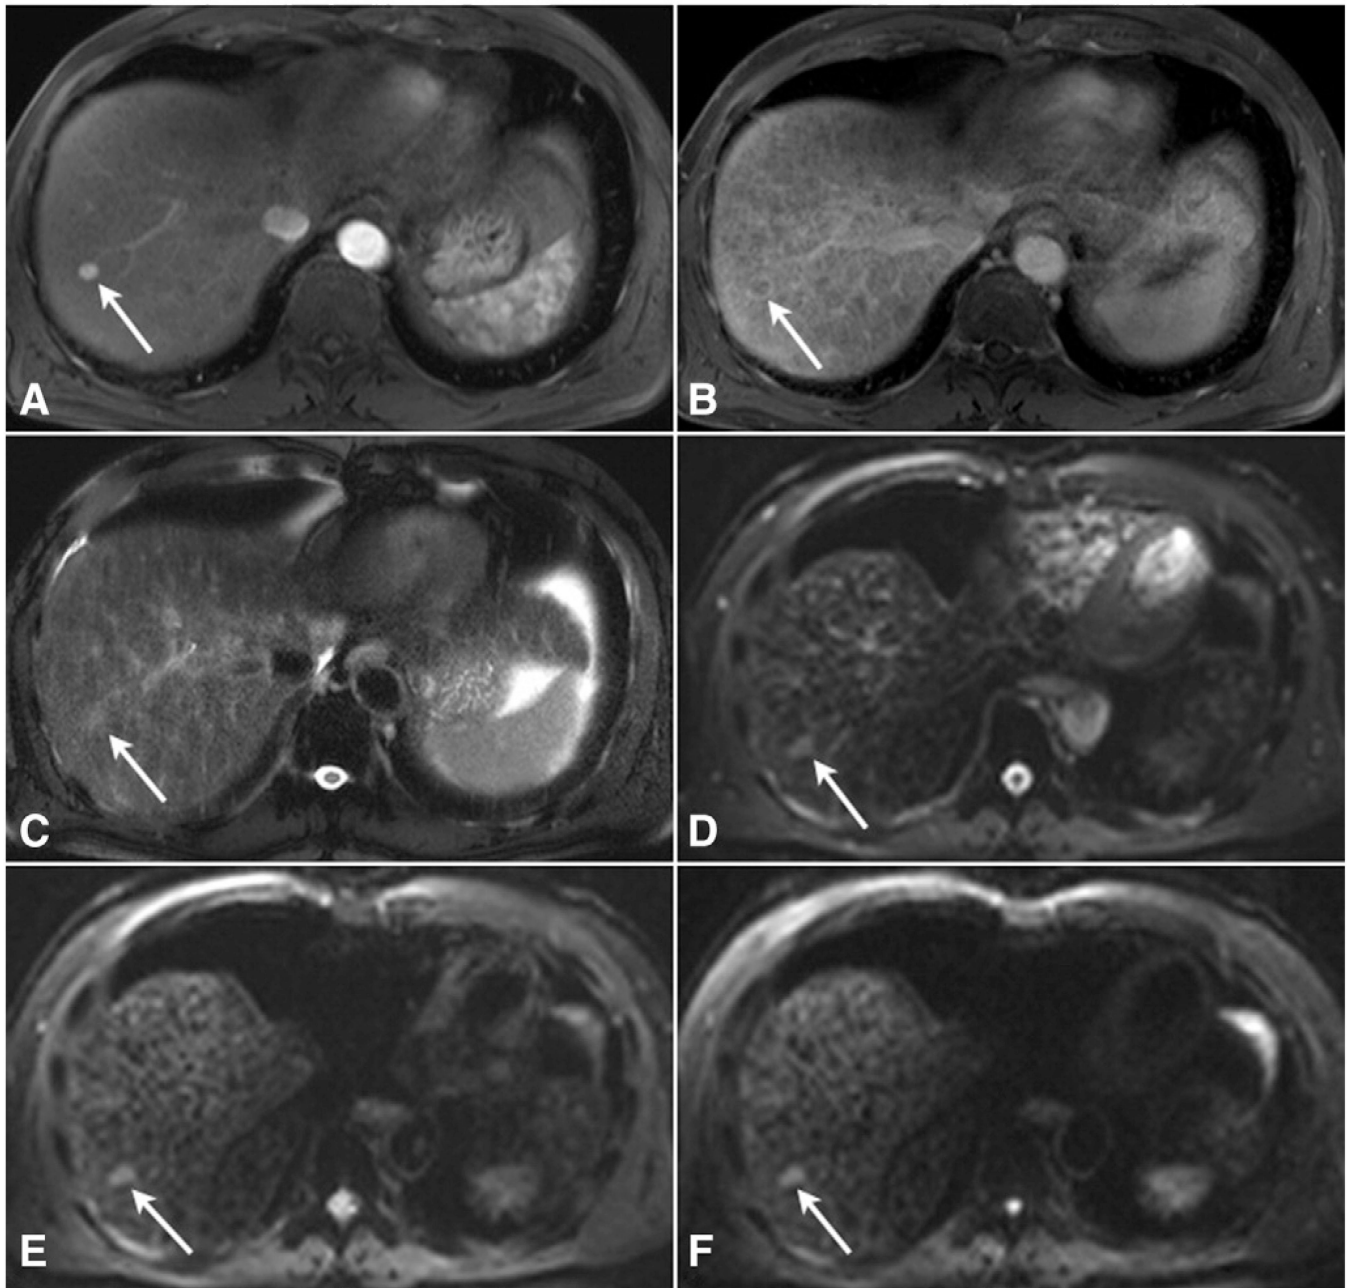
68-year-old male with a solitary arterially enhancing 3.0 cm hepatocellular carcinoma in segment VIII (A, arrow). 5-min delayed phase image (B, arrow) demonstrates washout appearance with associated capsule appearance, confirming LI-RADS 5 classification. The corresponding lesion was also seen on (C, arrow) T2 SSFSE images and on all DWI ( $b = 0$  and 700 shown, D–E, arrows) with corresponding ADC map (F, arrow).
